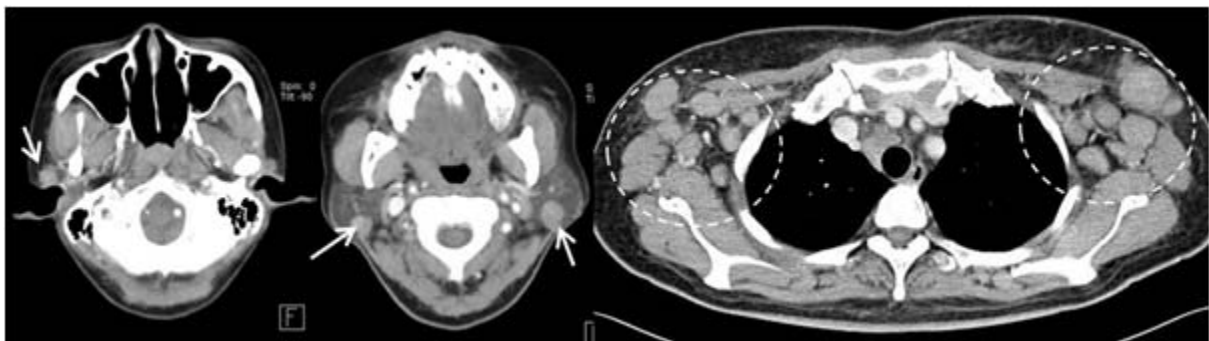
Intraparotid nodes. Enhanced axial CT scan revealed lymphoma at nasopharyngeal wall with intraparotid nodes (arrow) in bilateral parotid glands. There are multiple axillary (in dash circle), mediastinal and intraabdominal lymph nodes (not shown) on CT chest and abdomen. This patient had bone marrow involvement proved by biopsy.
